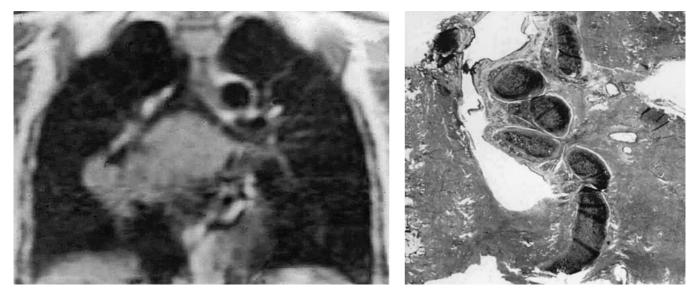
Magnetic resonance image showing bilateral compression of main bronchi by a subcarinal mass due to histoplasmosis in a 35-year-old woman. Extensive disease also encircles the bronchus intermedius. The lesion developed radiologically in less than 5 years. This required removal of middle and lower lobes in continuity with the subcarinal mass. The main bronchi were intact.
